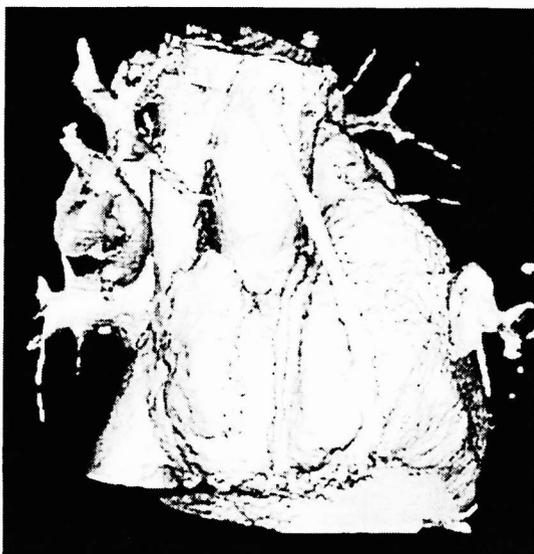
EBT CT coronary angiogram using intravenous contrast media. The native right coronary artery (center, lower half) shows evidence of multiple stenotic segments. The right bypass graft (center) has a normal, healthy appearance and is patent.
